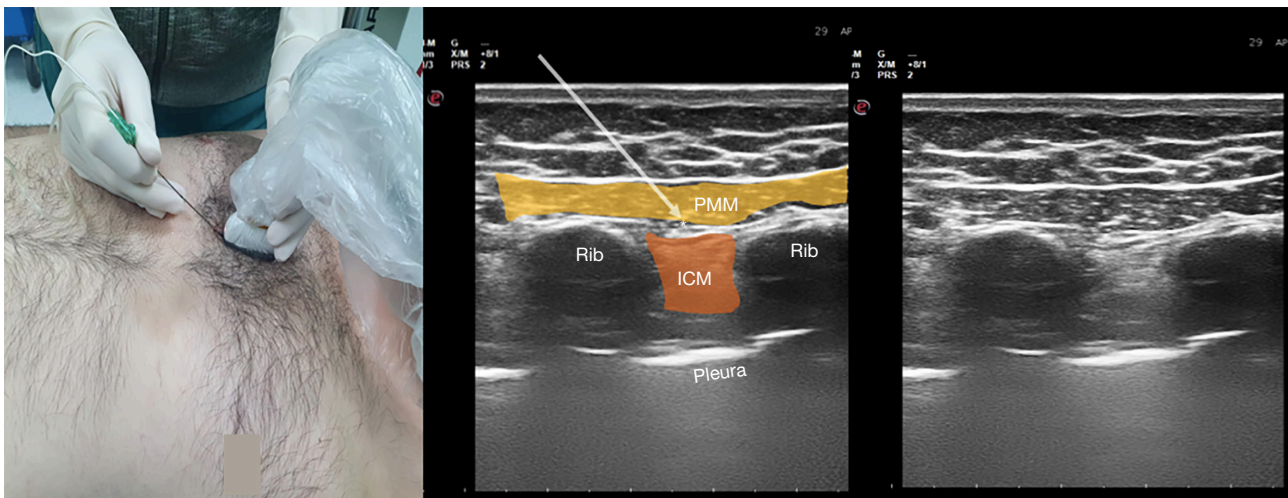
Ultrasound probe positioning and sonographic image of the pecto-intercostal fascial block. This image is published with the patient/participant's consent. *, needle tip place. PMM, pectoralis major muscle; ICM, intercostal muscle.
